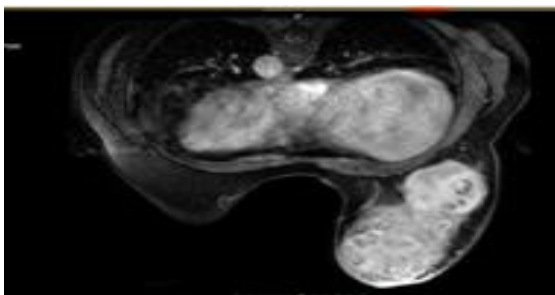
MRI showed Well defined round to oval lesion seen in outer quadrant of right breast in retroareolar region appearing hyperintense on T1 and suppressed on PD/FATSAT s/o lipoma. Multiple variable size lesions noted in left upper quadrant appearing hypointense on T1, hyperintense on T1/STIR s/o multiple fibroadenoma. Axial t2/stir image showing hyperintense ill defined lobulated mass lesion in right breast showing few non enhancing areas. Small tiny cyst noted in retroareolar region of left breast.
